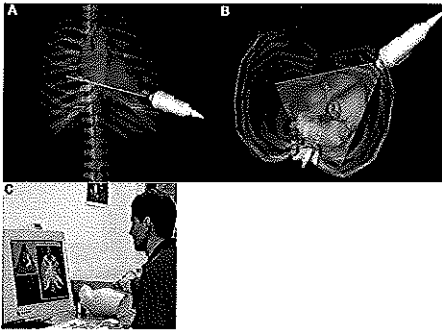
In panel A, the VR model is placed into a VR thorax. A VR echocardiogram probe is modeled with representation of an ultrasound field. The operator holds a dummy echo probe on a dummy thorax. A magnetic field and a sensor attached to the dummy probe, register motion of the transducer. The operator can now perform a virtual echocardiographic examination on the dummy patient, rotating the model probe to view how the ultrasound field is cross-sectioning the heart. The model can be linked to 'real' echocardiographic image data, making the examinations even more realistic.
